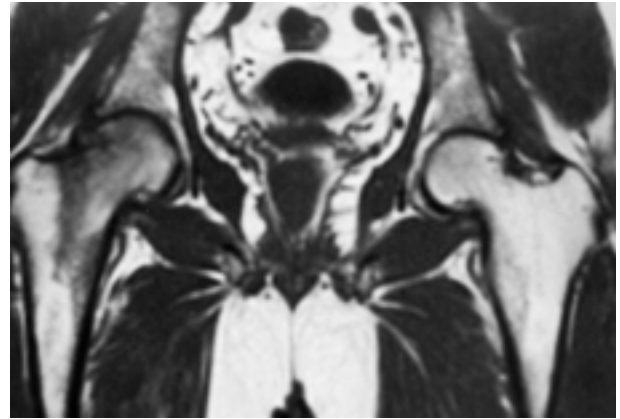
T1-weighted image in MR reveals diffuse and homogeneous low signal intensity throughout the right femoral head and neck, not affecting the acetabular and trochanteric regions (same patient as fig. 1).
